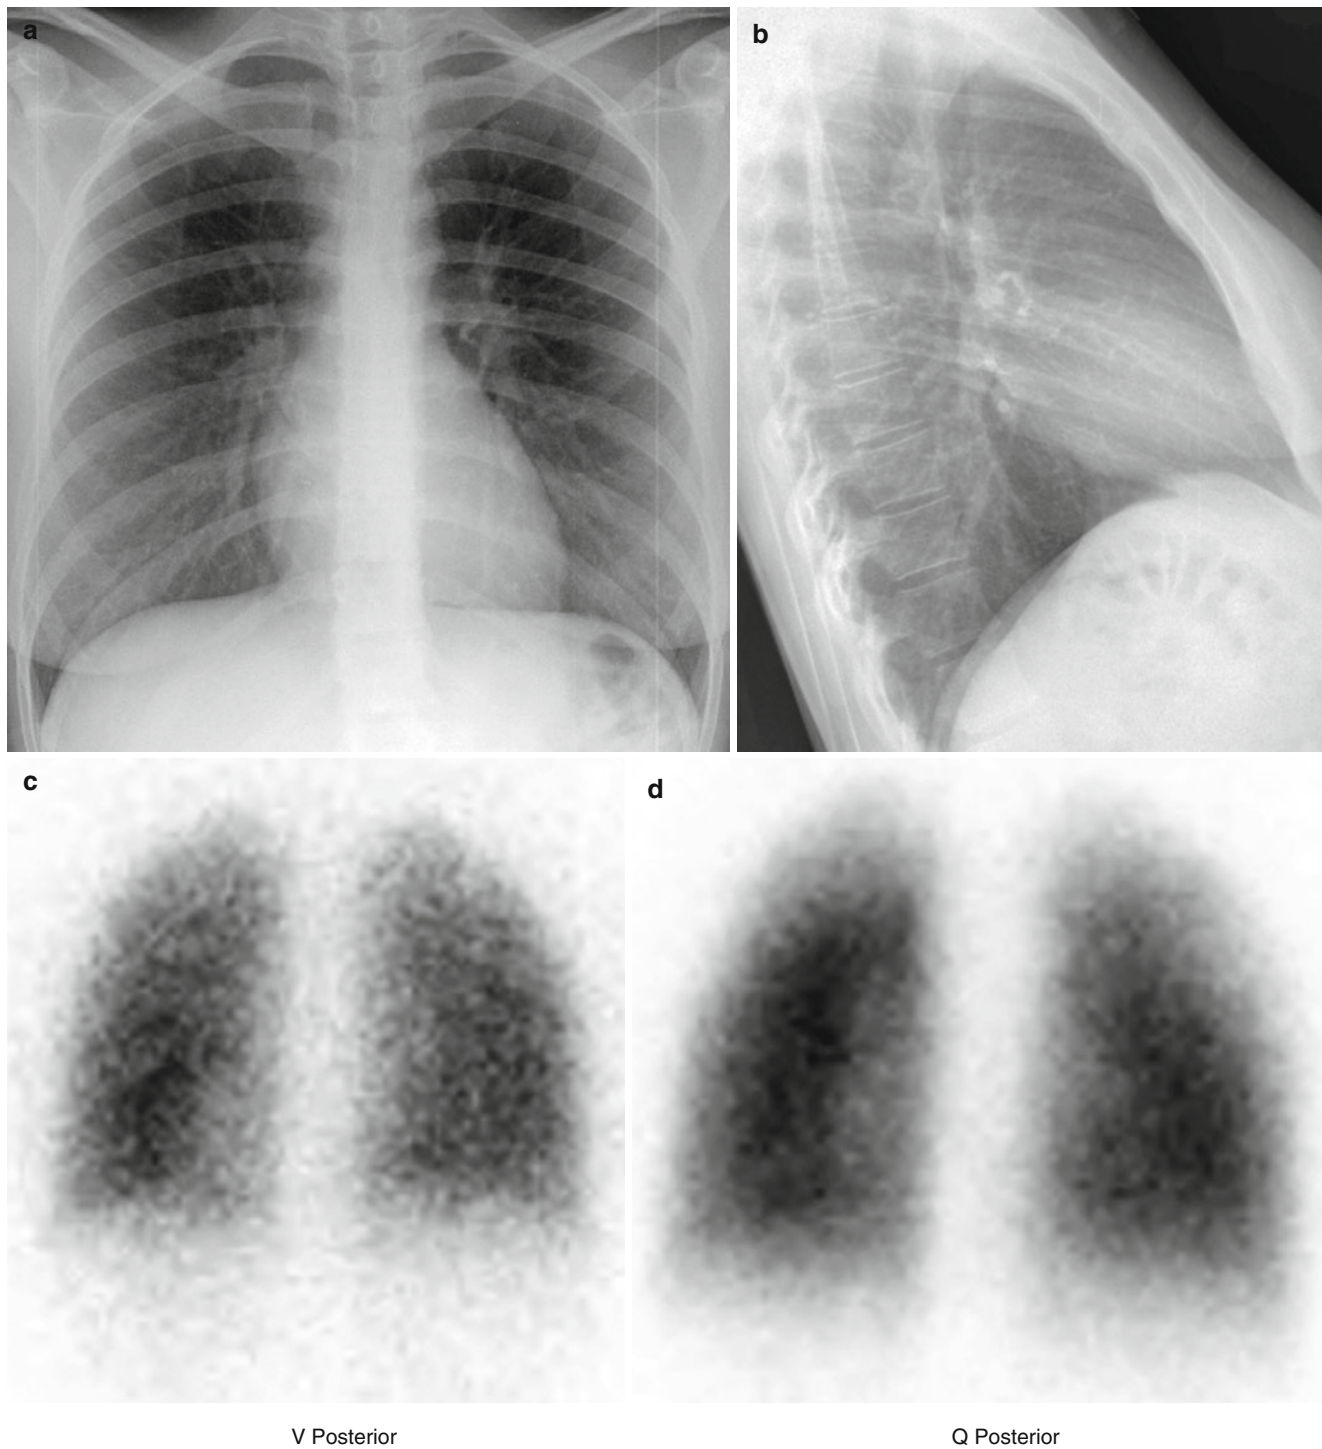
Normal. Normal posterior-anterior (a) and lateral (b) chest radiographs. Normal ventilation (c) and perfusion (d) scintigraphy performed with ^{133}Xe gas (ventilation) and $^{99\text{m}}\text{Tc}$ MAA (perfusion)
